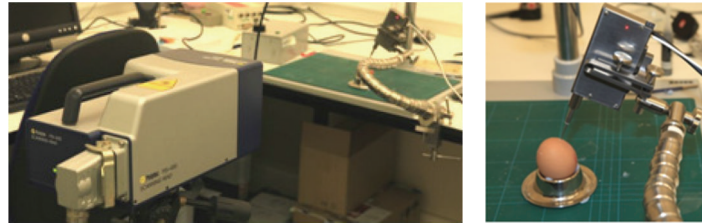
Setup of a laser Doppler vibrometer to evaluate disturbance velocity amplitude [14].
